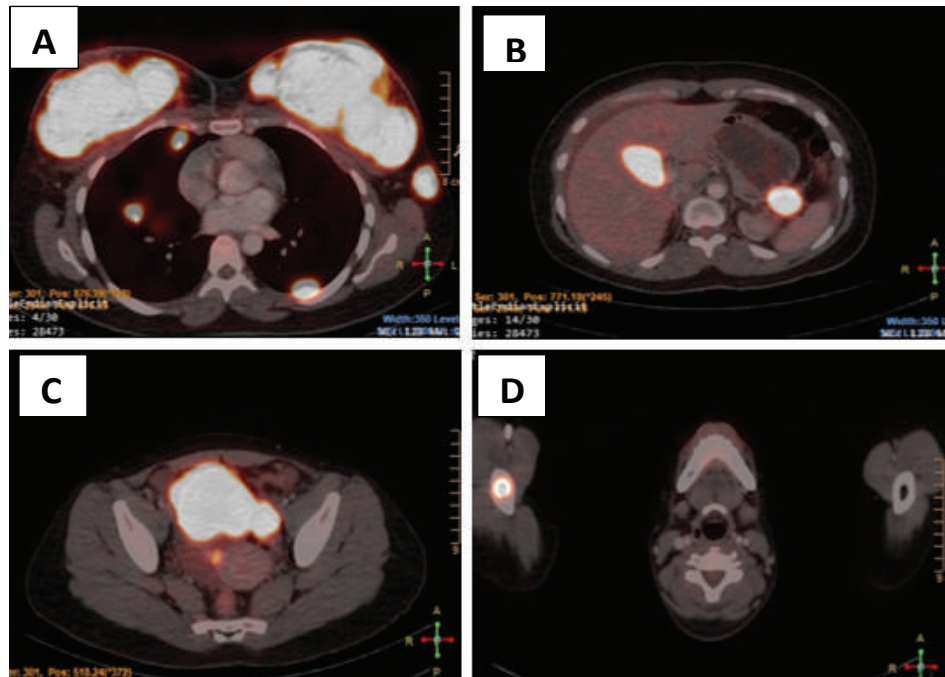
^{18}F -FDG PET-CT fused axial images in a 28-year-old female presented with breast enlargement and revealed intensely hypermetabolic soft tissue masses in both breasts (A). Hypermetabolic lesions involving both lungs, axilla (A) and upper abdominal lymph nodes (B), peritoneum (C) and skeleton (D).
